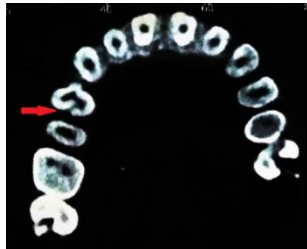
Axial view of CBCT revealing root perforation (red arrow)
